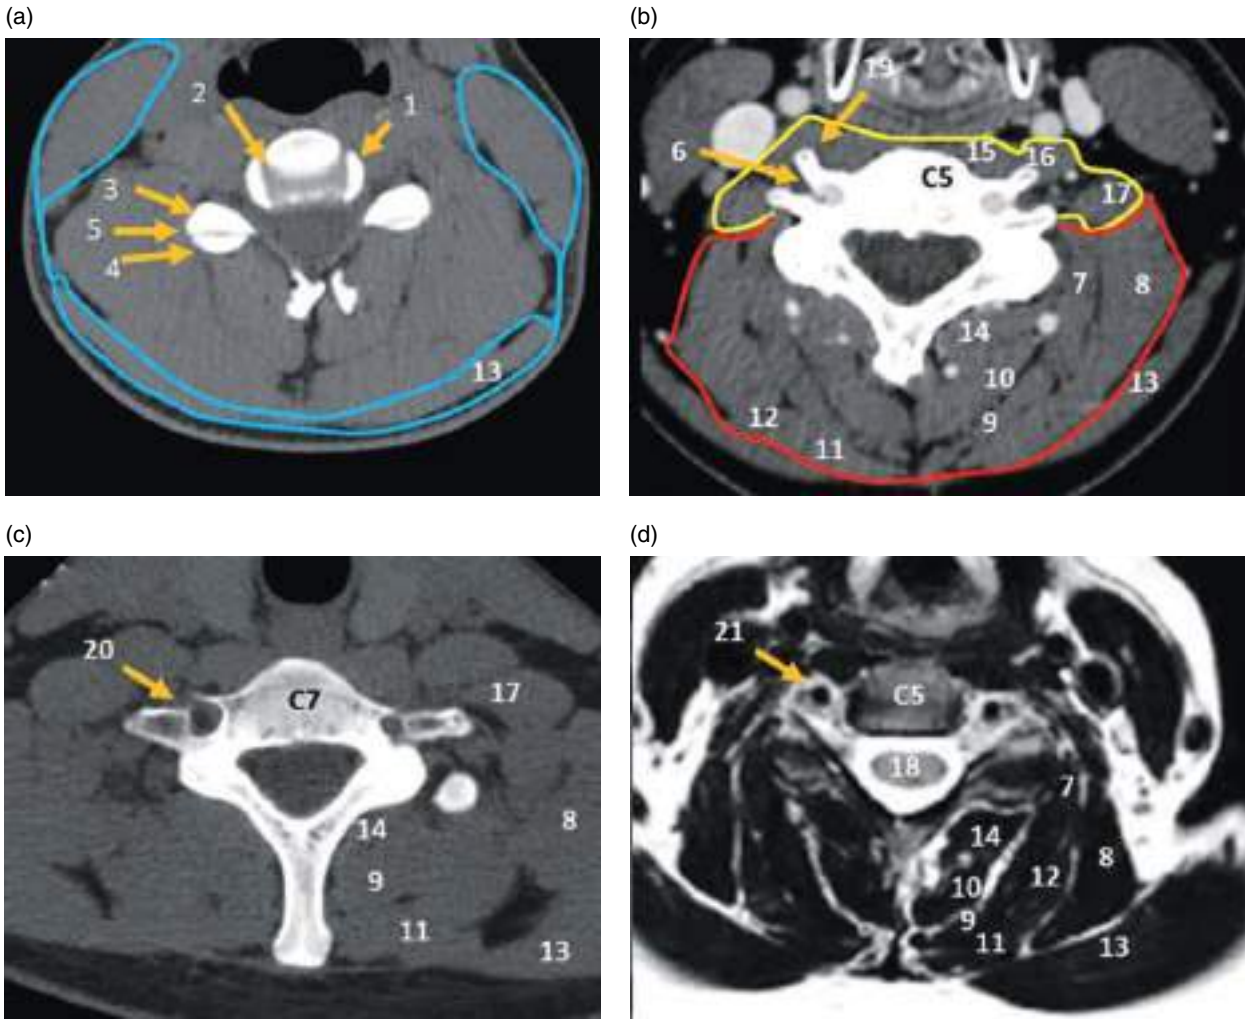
Axial CT image at the level of the C4–C5 disc (a), C5 vertebral body (b), and C7 vertebral body (c). (d) Axial T2-weighted MRI at the level of the C5 foramina. 1, uncinata process of C5; 2, uncovertebral joint of C4–C5; 3, superior articular facet of C5; 4, inferior articular facet of C4; 5, facet joint; 6, vertebral artery foramen; 7, longissimus cervicis muscle; 8, levator scapulae muscle; 9, semispinalis capitis muscle; 10, semispinalis cervicis muscle; 11, splenius capitis muscle; 12, splenius cervicis; 13, trapezius muscle; 14, multifidus muscle; 15, longus colli muscle; 16, longus capiti muscle; 17, scalenus medius muscle; 18, spinal cord; 19, costotransverse process of C5; 20, costotransverse process of C7; 21, vertebral artery. The blue line represents the superficial layer of the deep cervical fascia encasing the trapezius and sternocleidomastoid muscles. The perivertebral space is subdivided into prevertebral (yellow) and posterior paraspinal (red) spaces.
